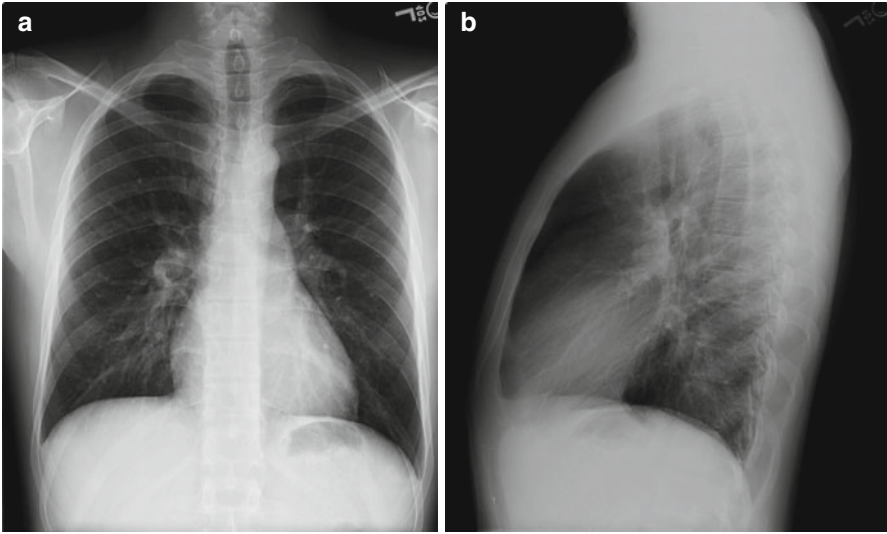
(a, b) Prominent pulmonary artery and right ventricular enlargement. (a) PA chest radiograph. (b) Lateral chest radiograph
